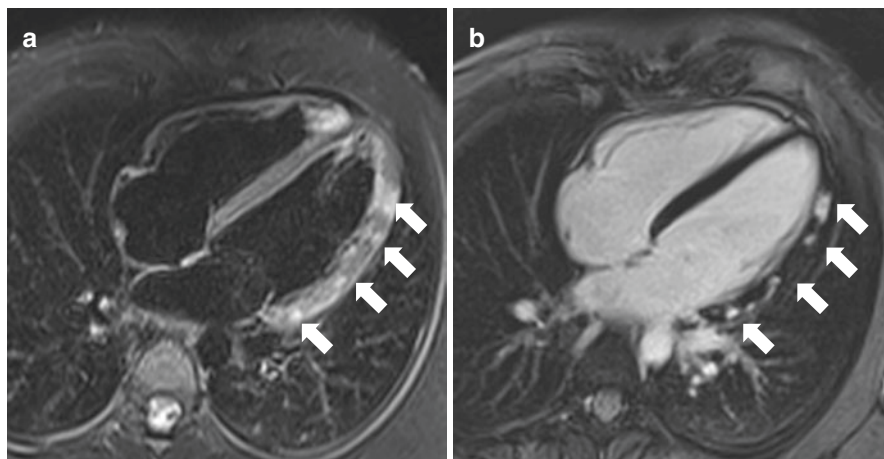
Typical CMR feature of myocarditis. A typical case of acute myocarditis is shown on (a) (T2-weighted sequence, long axis view): the bright signal intensity with epicardial–midmural pattern on left ventricular wall (white arrows) represents areas of myocardial edema due to inflammation. On post-contrast sequence (b, long axis view) area of late gadolinium enhancement (white arrows on b), spatially corresponding to patchy edema on (a), represents area with more pronounced myocardial damage including necrosis
